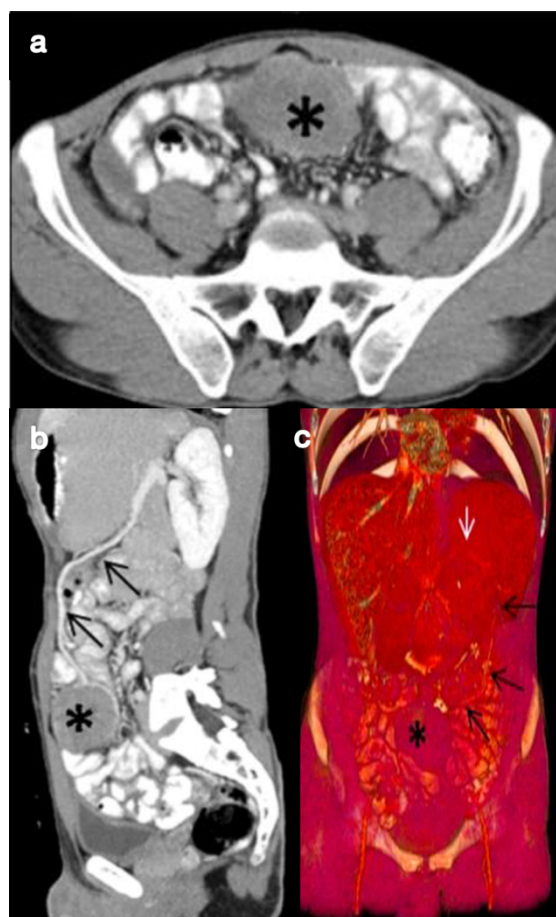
(A), Axial computed tomography of the abdomen in axial section showing omental mass, (B), sagittal section of the tomography where the omental vein is observed reaching what would be the omental mass. (C), coronal section where it is observed that the omental vein drains to the splenic vein.
